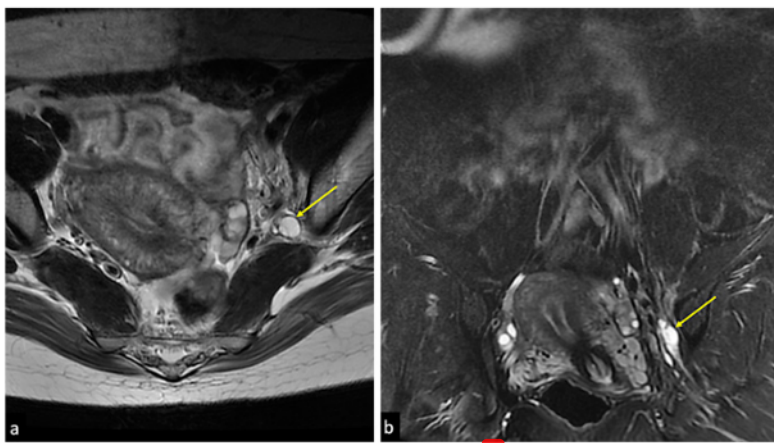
a MRI evaluation after surgery. b Axial coronal T2-weighted sequence demonstrating a small residual cystic mass in the anteromedial left sciatic notch with a size of $\pm 1.03 \times 0.78 \times 2.60$ cm.
